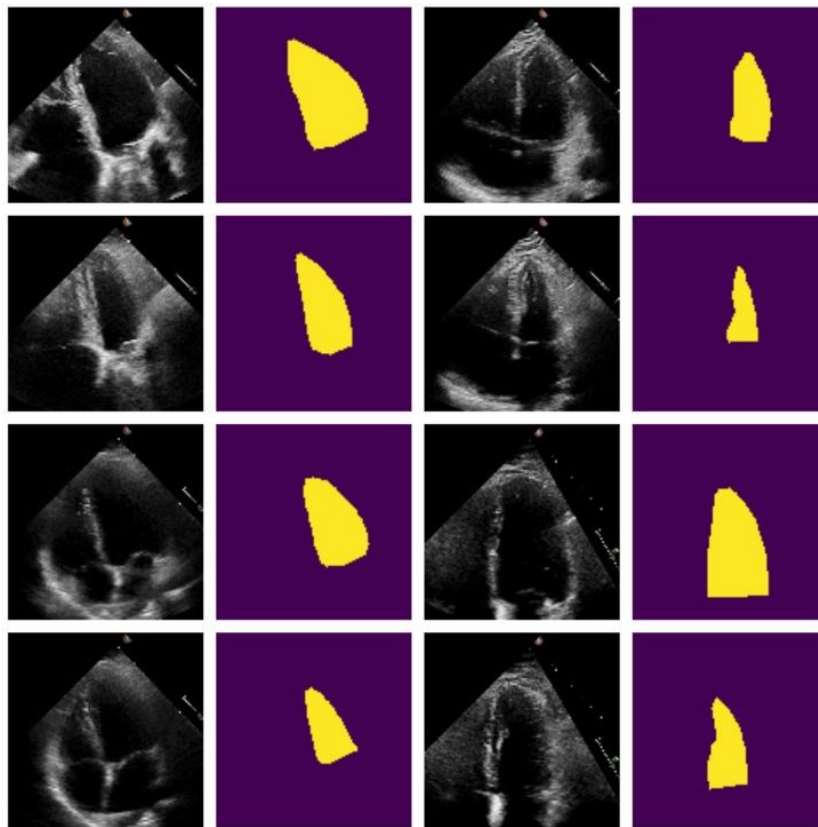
Random samples of echocardiographic images and corresponding masks from the EchoNet-Dynamic dataset.
